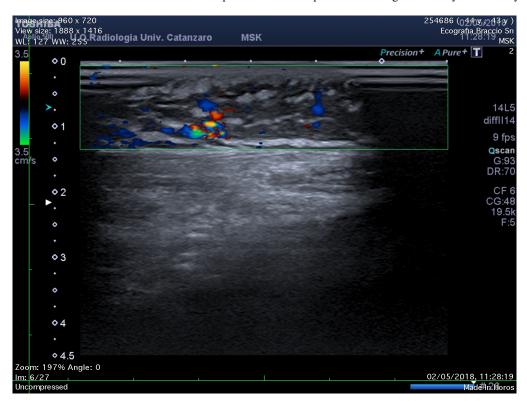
Ultrasound of the forearm: it is possible to note inhomogeneity of the sub-cutis with tissue edema and marked structural disruption of the subcutaneous adipose panniculus.
